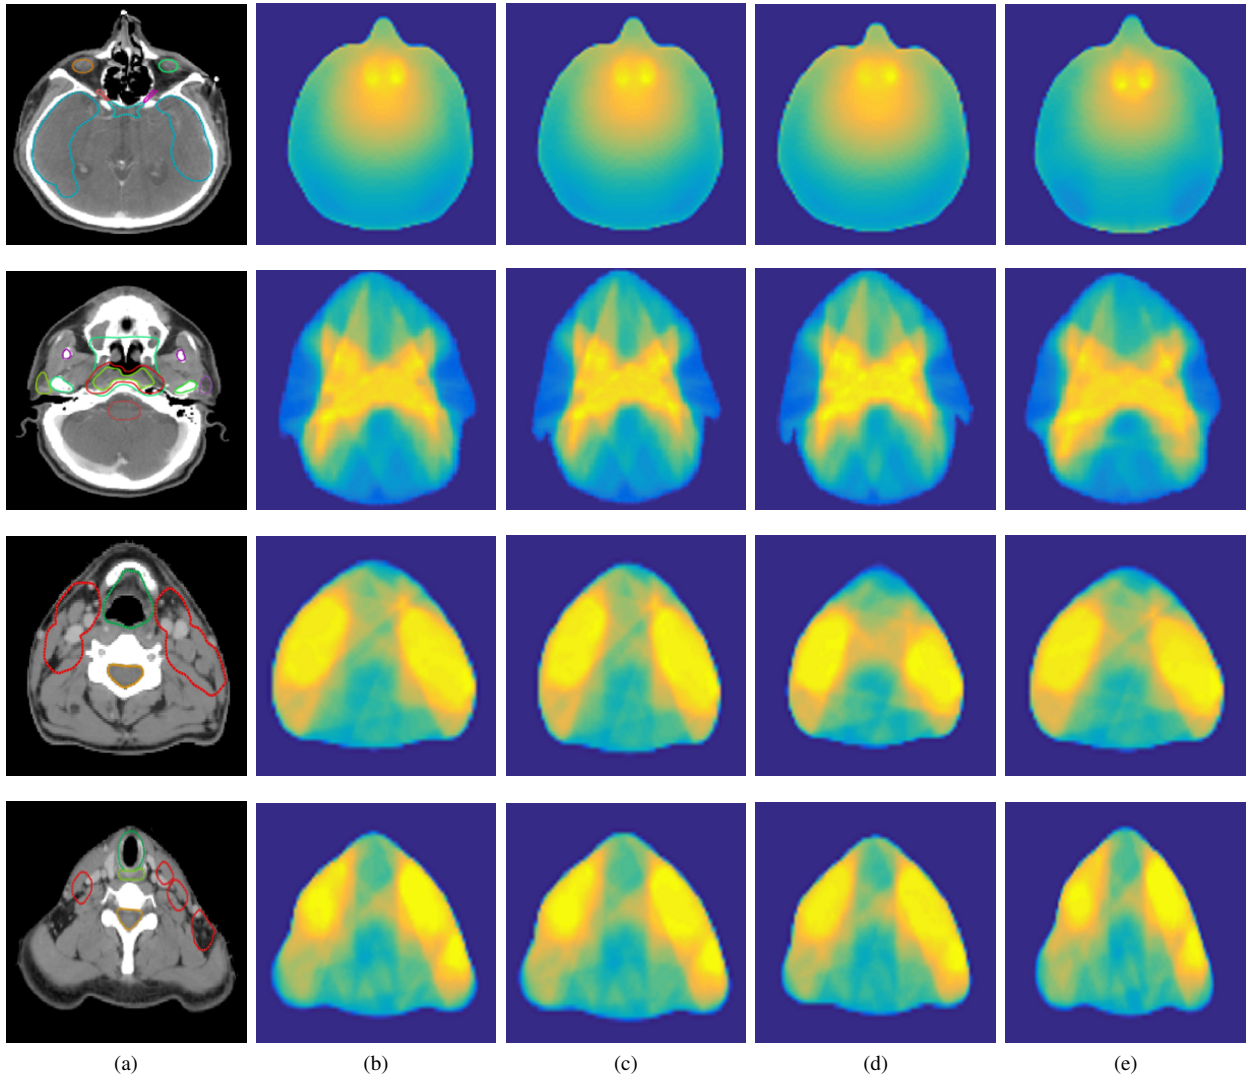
Examples of (a) contoured CT image and its dose distribution obtained by (b) Ground-truth, (c) Ours, (d) GAN and (e) ResNet101 with the integration network.
